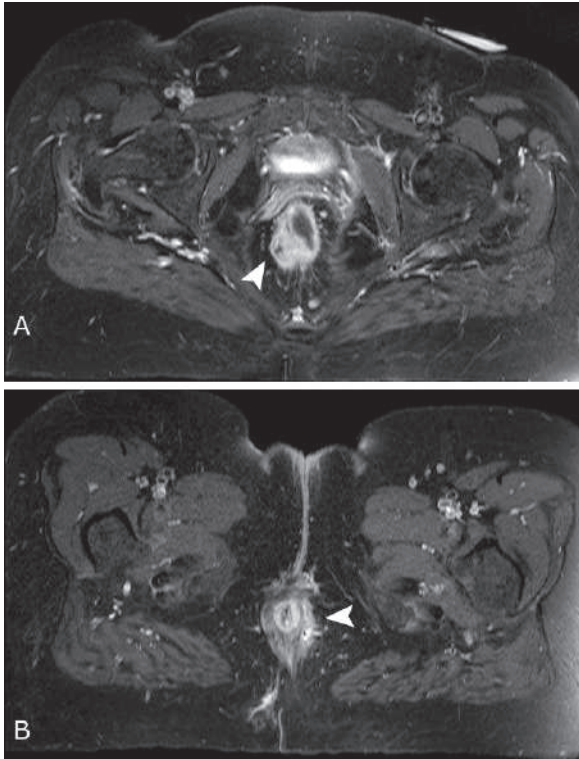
Axial T1W postcontrasts with fat-saturation pelvic MRI in a patient with CD and fistula-in-ano seen as abnormal tract parallel to the anus in (b) and extends up to the rectum in (a) with contrast enhancement of the fistula wall (*arrowheads*)
